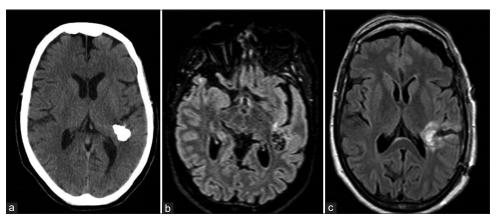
Preoperative neuroradiological assessment. Computed tomography scan (a) demonstrating the presence of a densely calcified left temporal and insular lesion. FLAIR sequences of magnetic resonance (MR) scan confirmed the presence of the calcified tumor (b). Postoperative MR confirmed the complete resection of the lesion (c).
